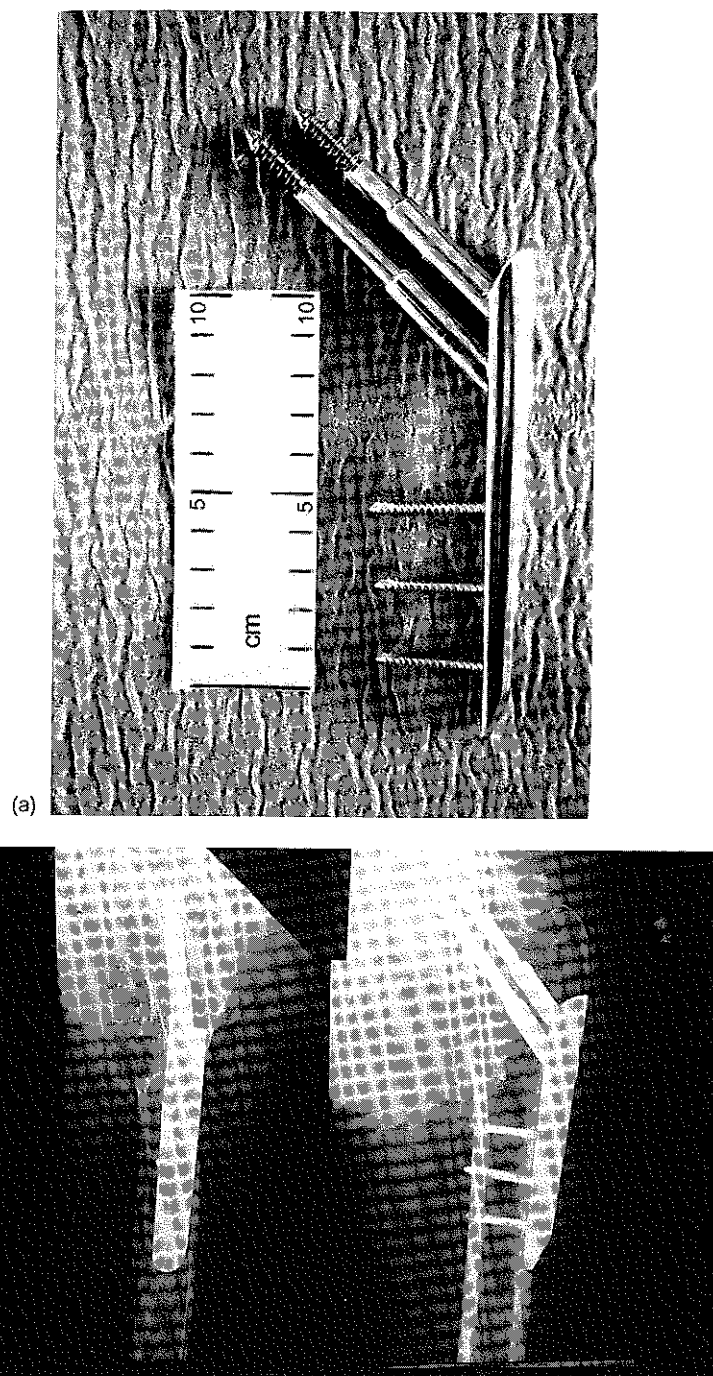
(a) The PCCP consists of a plate with a knife-like end and two neck screws of 9.3 mm diameter (self-cutting). Dynamization can take place because of the telescopic design. (b) Radiograph of a hip fracture treated with the PCCP.
